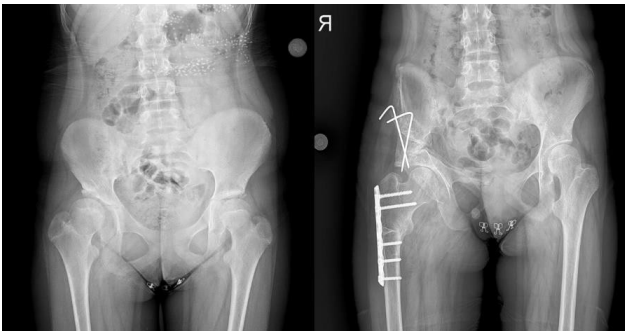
Preoperative and postoperative 6th months X-rays following triple pelvic osteotomy, femoral shortening and derotation surgery
